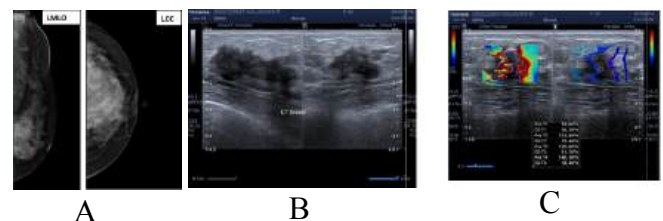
Multimodality imaging correlation of a breast lesion: (A) mammography showing irregular mass, (B) Bmode ultrasound demonstrating hypoechoic lesion, and (C) SWE showing increased stiffness.
